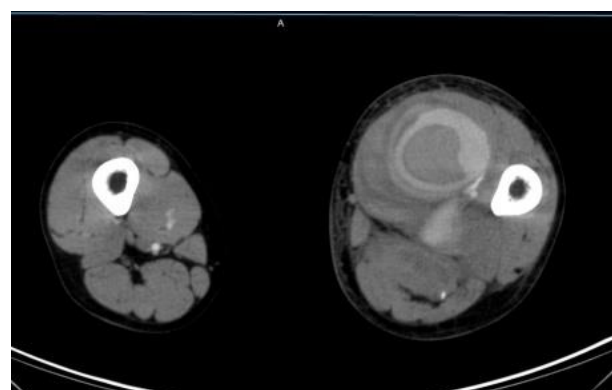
Left femoral artery pseudoaneurysm in axial view on CTA with injection of iodized contrast.
